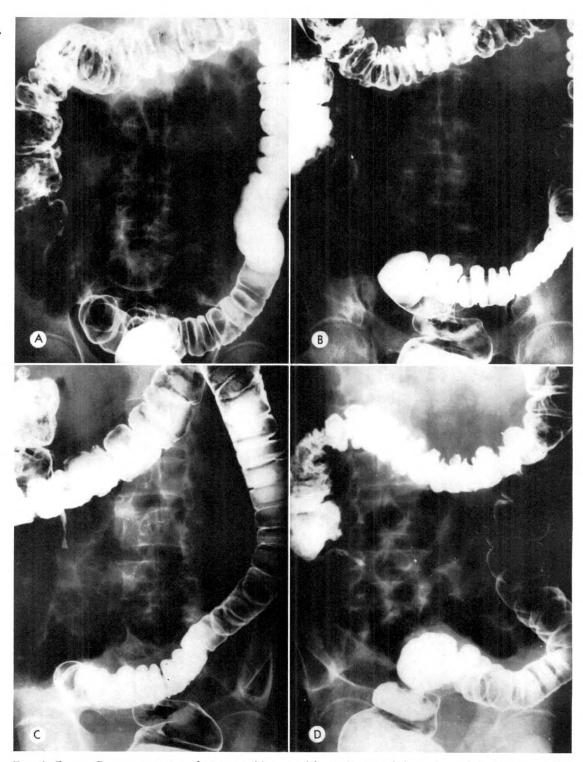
Case 1. Roentgenograms of 58 year old man with carcinoma of the rectum. (A) Anteroposterior view. (B) Posteroanterior view. (C) Left anterior oblique view. (D) Right anterior oblique view.
